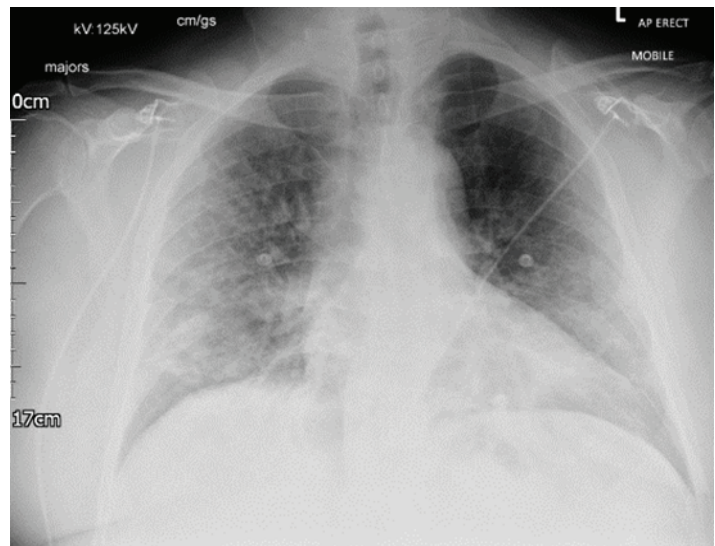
AP chest radiograph demonstrating bilateral, mid and lower zone predominant patchy parenchymal infiltrates in keeping with moderate/severe COVID-19 pulmonary infection. (AP – anteroposterior).
